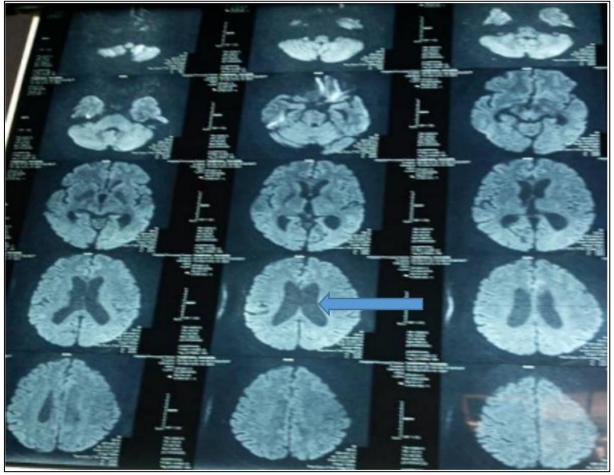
Ventricular dilatation in axial section of MRI angiography
